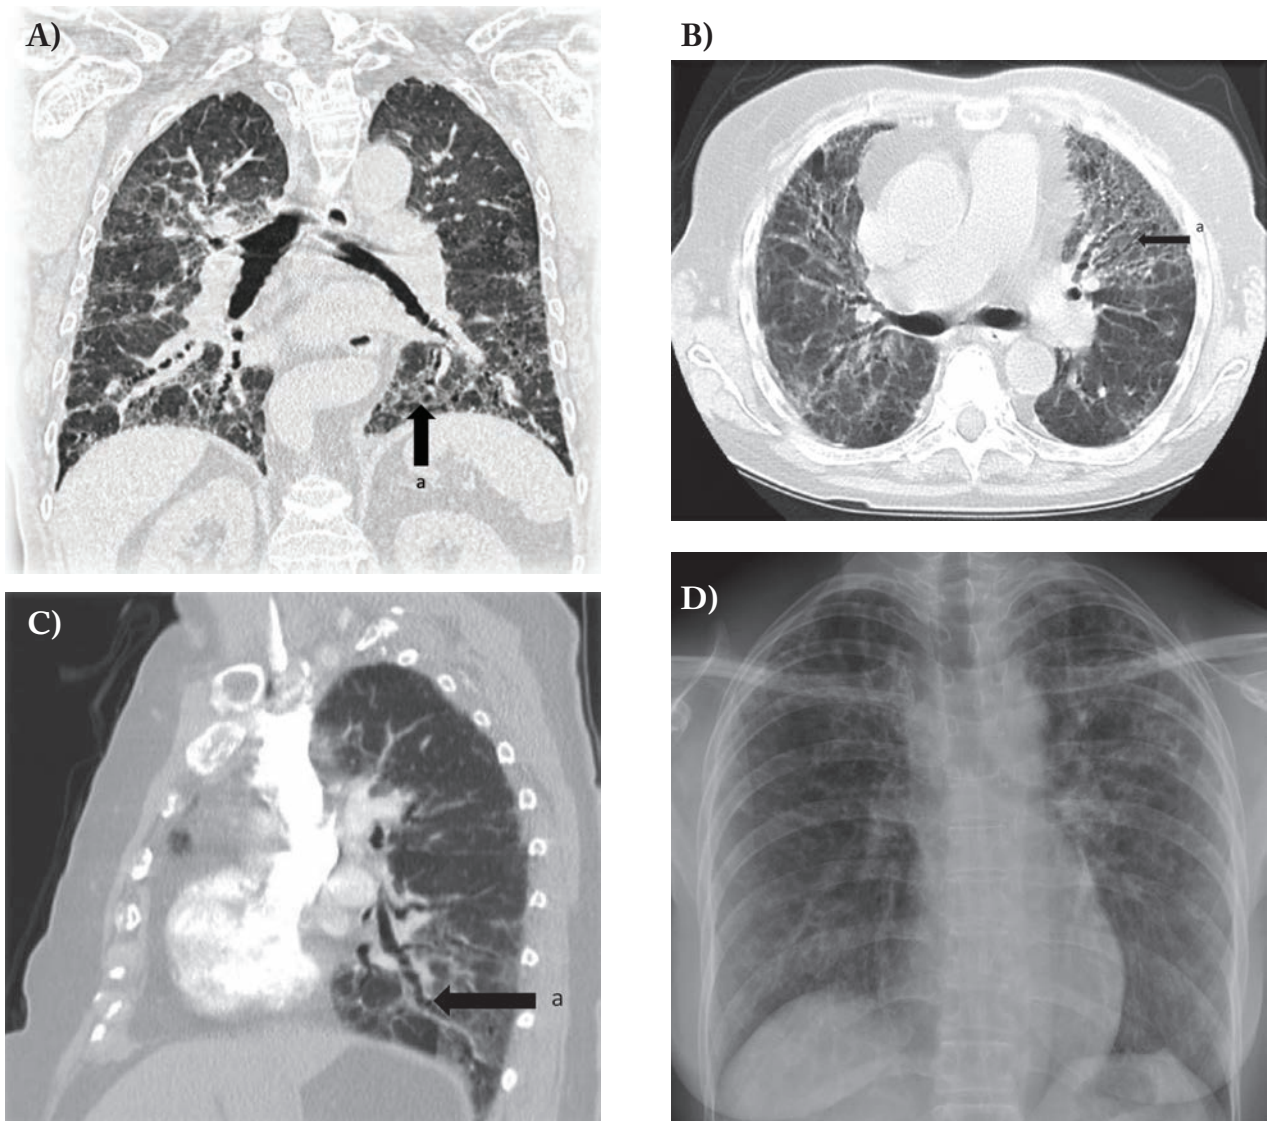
A) High Resolution CT-Scan (coronar plane): a = occasional interstitial thickening; B) High Resolution CT-Thorax (axial plane): a = thickened airway walls, traction bronchiectasis; C) High Resolution CT-Thorax (sagittal plane): a = thickened airway walls; D) Chest radiograph: cranial accentuation
